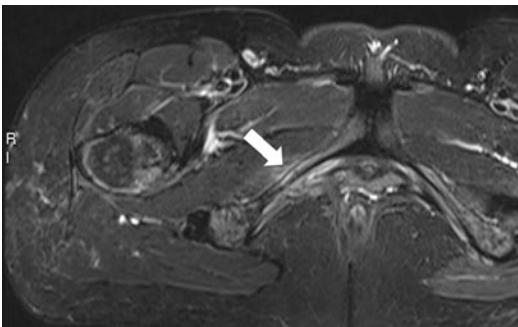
STIR-weighted MRI axial view of the pelvis shows bone marrow edema of the right pubic branch and around soft tissues (*white arrow*), which is a sign of a radiographically occult fracture
